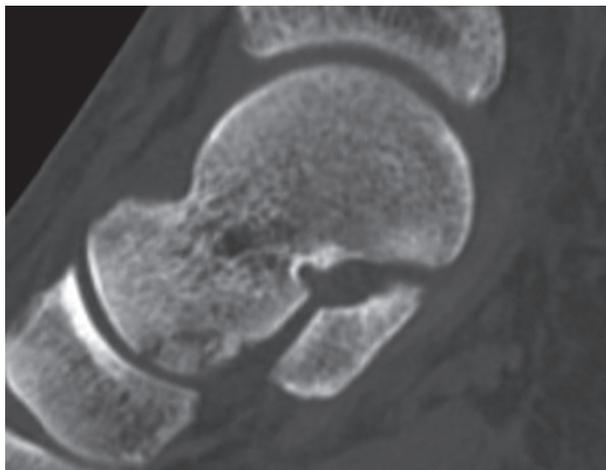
Simple shear fracture of the head (sagittal CT MPR)
